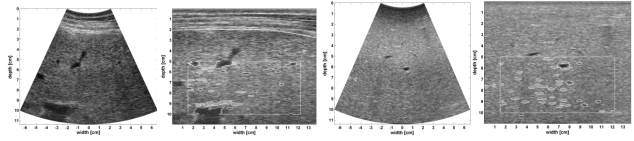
Transc and Intraop ultrasound liver images. (a) Scan-converted Transc sector image. (b) Transc back-scan converted sector image with interactively drawn fat-layer contour (white dashed line), applied: Transc normal group automatic gain compensation (AGC), fat-layer attenuation correction and automatic segmentation of hepatic blood vessels and bile ducts. (c) Scan-converted Intraop sector image. (d) Back-scan converted Intraop sector image with applied Intraop normal group AGC
